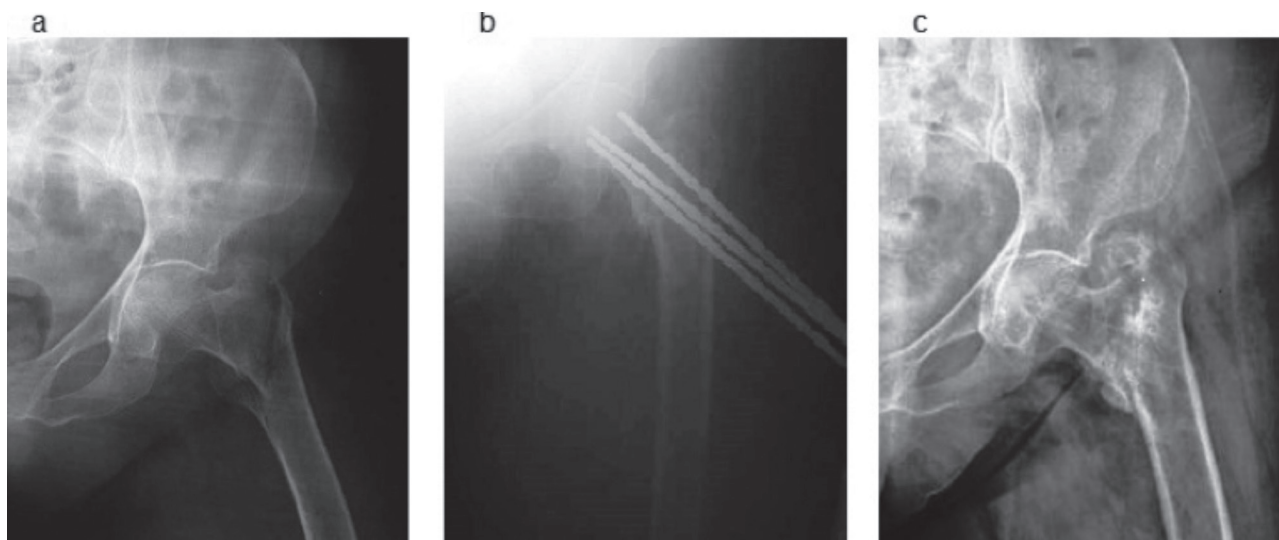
Radiographic images of an 82-year-old female treated using external fixator (a) preoperative, (b) postoperative, (c) after removal of fixator.
